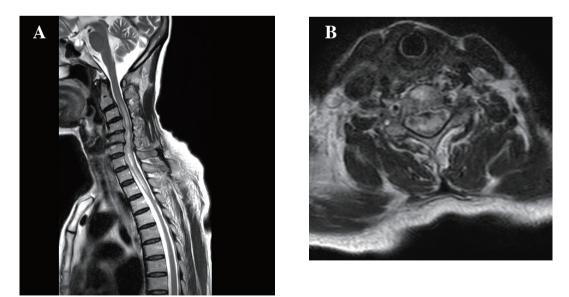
Spinal cord magnetic resonance imaging (MRI). (a) Sagittal T2-weighted MRI obtained on day 13 of symptom onset revealed increased intramedullary intensity lesion at the level of C2 to T3. (b)Transverse section of spinal MRI at C6 revealed mild cord edema with increased signal within the central gray matter of the spinal cord.
